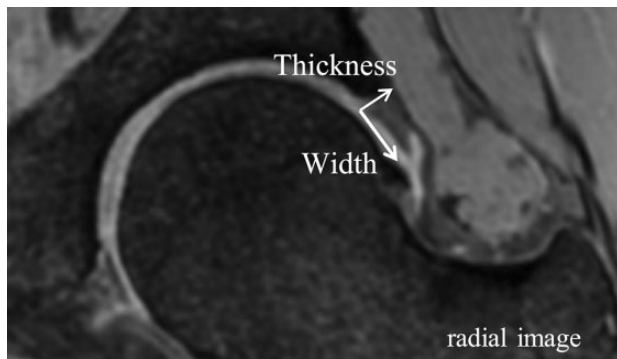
Labral thickness and width on multiple echo recombined gradient echo magnetic resonance imaging scan of a left-side hip joint. We measured the thickness of the acetabular labrum at the rim and the width to the apex of the acetabular labrum in the anterior region (2-3 o'clock), anterolateral region (1-2 o'clock), and lateral region (12-1 o'clock).
